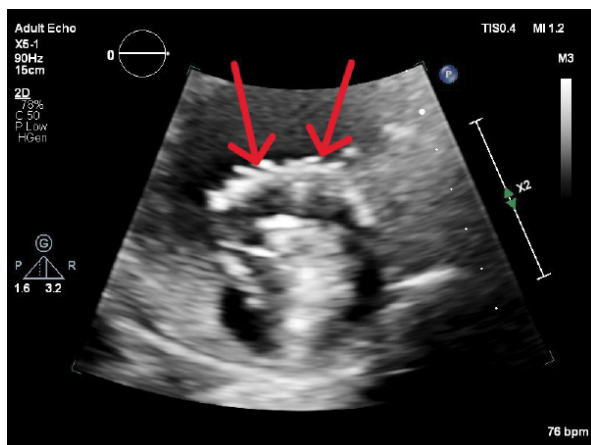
Short-axis ECHO of the left ventricle. Normal function of the mechanical valve, without residual paravalvular leakage. Typical echocardiographic image of the implanted artificial valve in the mitral field, which produces ultrasonic reverberations and shadows (so-called multiple reflections) that make direct ECHO imaging of the valve function difficult (arrows)
